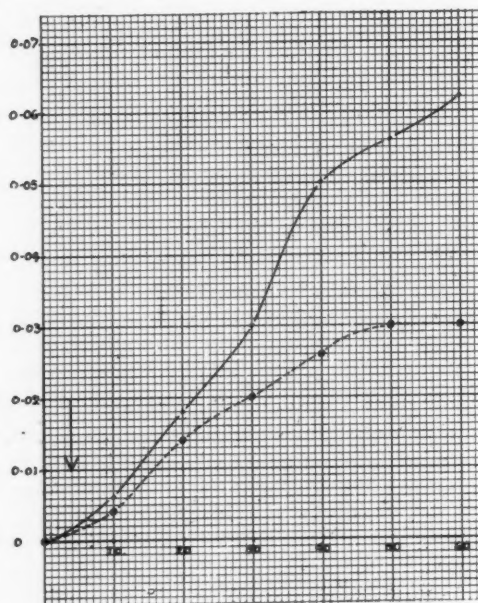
Sedimentation curve. The straight line represents the control tube, the dotted line the irradiated tube. The time is given in minutes, the ordinate shows the sedimentation-coefficient. The arrow indicates when X-ray exposure took place.
